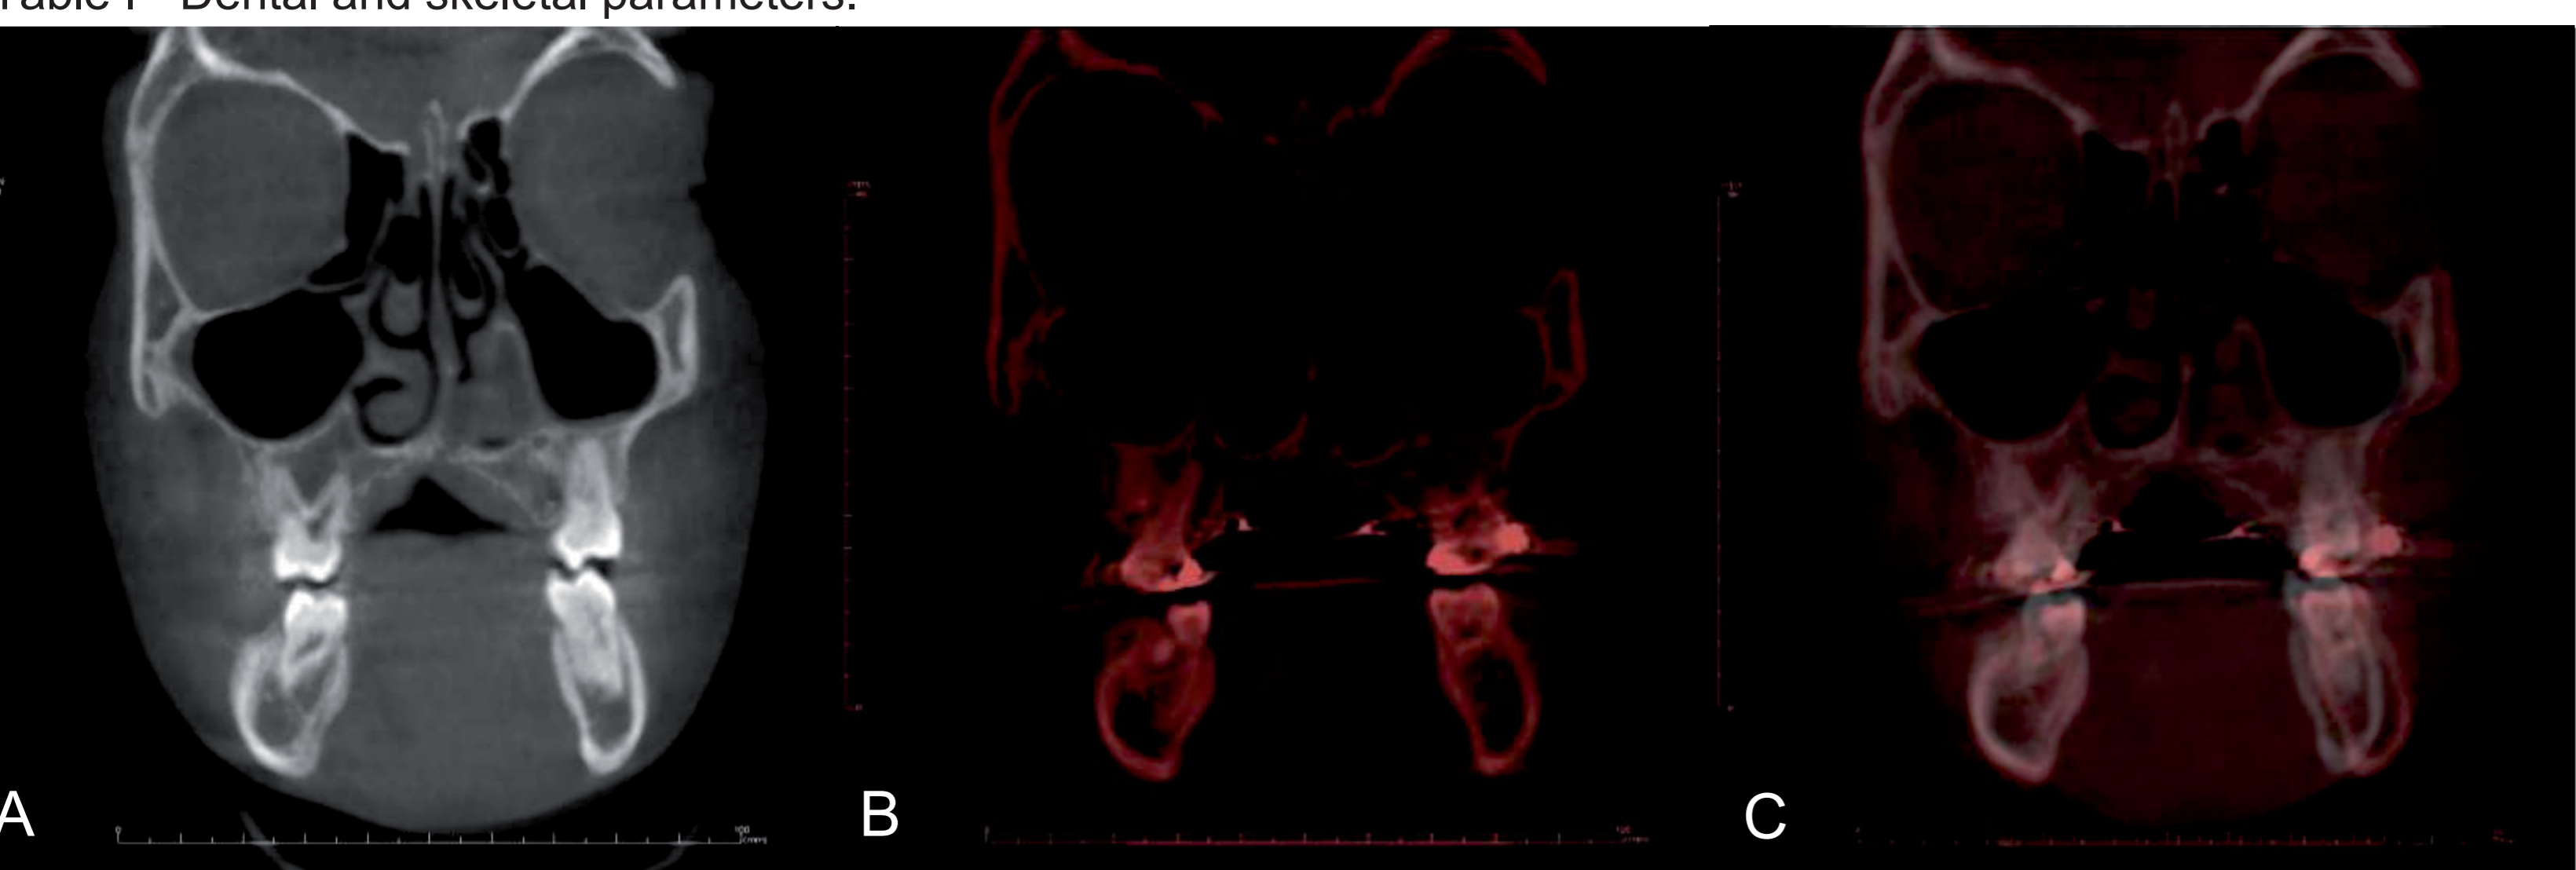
Coronal view of the posterior teeth pre-expansion CBCT
